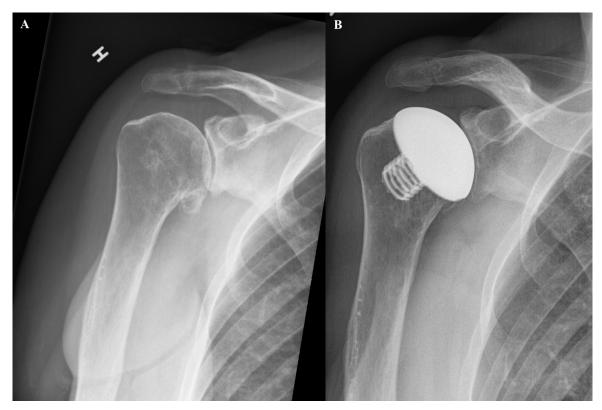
Anteroposterior radiographs. Preoperative (A) and at last follow up 8 years after surgery (B). This patient had an improvement in ASES from 22 to 89, and in CS from 36 to 100, and VAS 0 at follow up. No caput migration, glenoid OA or radiolucency was observed.
